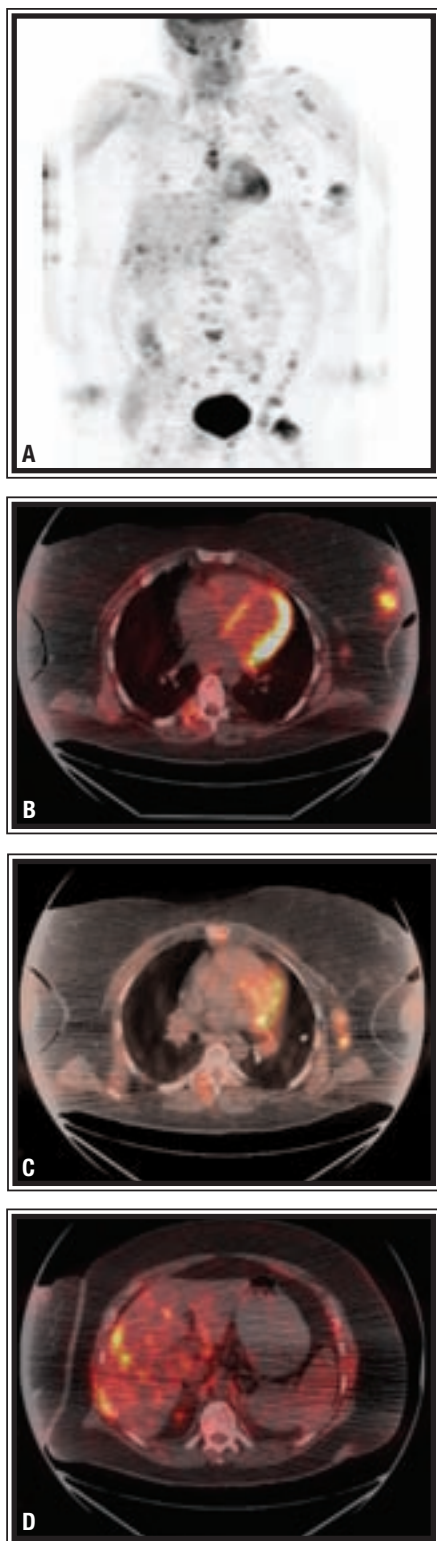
35-year-old woman presented with left breast 3-cm cancer. Left axilla was clinically negative. A: Maximum intensity projection image shows widespread metastatic disease. Precise localization of lesions is difficult to assess without CT framework. B: PET/CT shows left breast cancer. C: Axillary lymph nodes. D: Liver and rib metastases.
